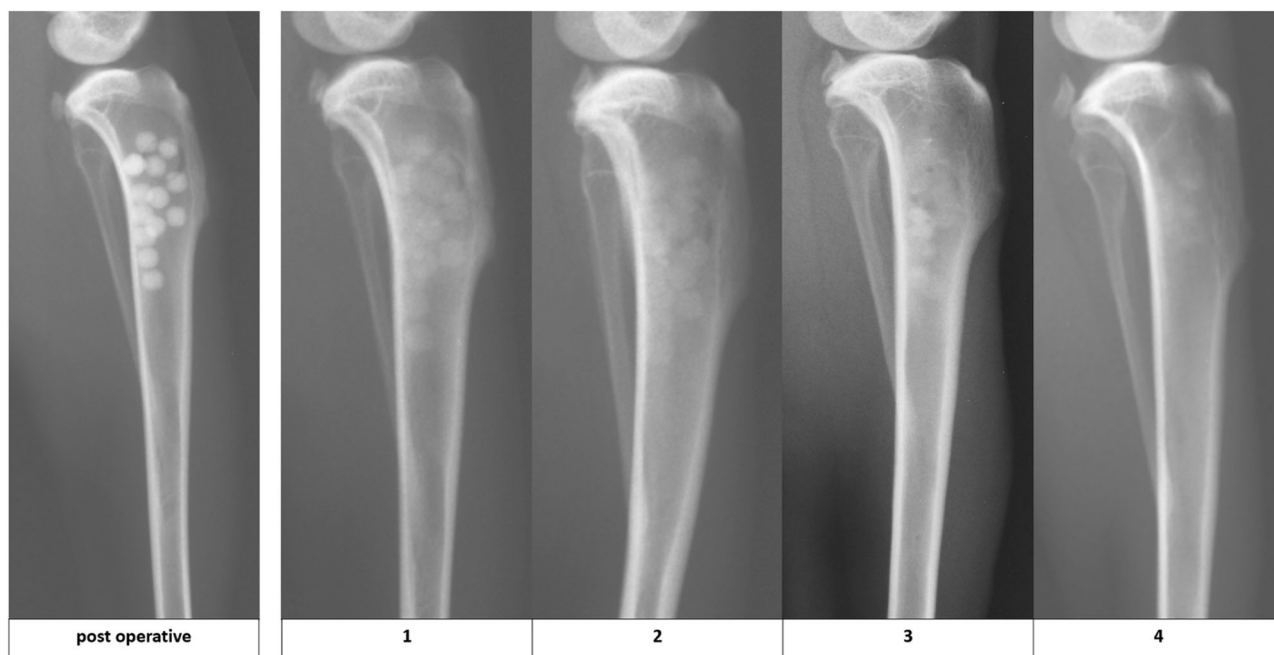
Scoring system for radiographic changes. Scoring system for x-ray pictures to evaluate the grade of resorption (1: radiopaque locally reduced; 2: radiopaque uniformly reduced; 3: implants shadowy; 4: implants completely disbanded)
